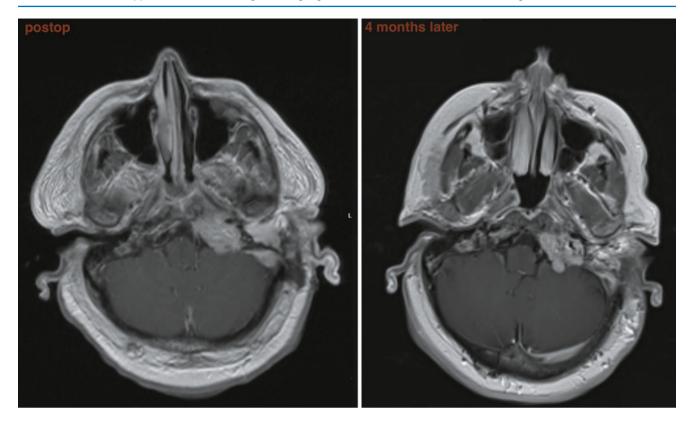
Postoperative MRI, axial
